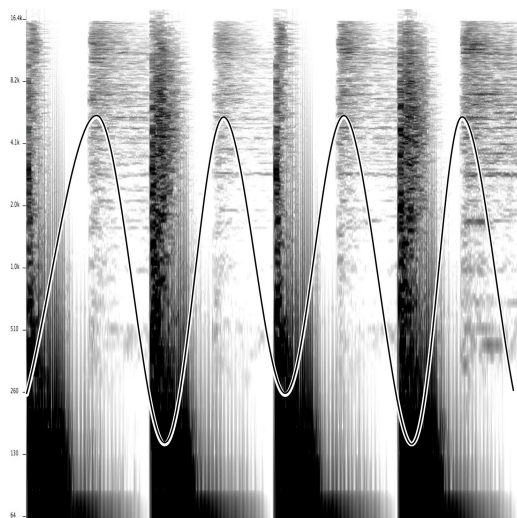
Sonogram with suggested movement curve for Hercules and Love Affair, *Blind* (Frankie Knuckles Remix), 0:05–0:07.
